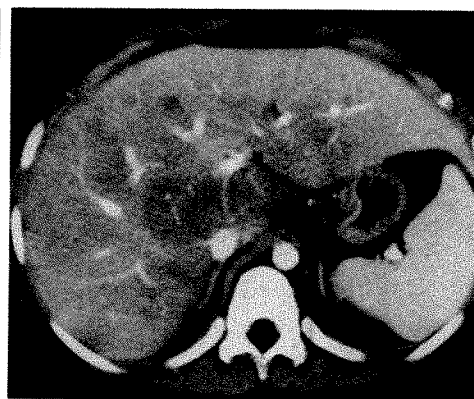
Bolus effect. An aortocaval contrast density difference of greater than 30 H allows detection of infiltrative disease throughout liver on CT scan of 7-year-old boy. Note bolus effect in Fig. 1 also.
